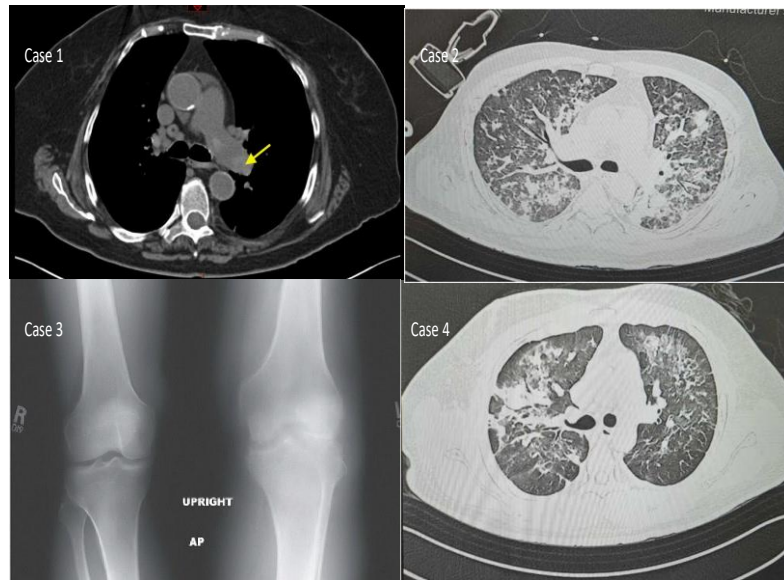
Radiological findings of patients: Case1; Computed Tomography of pulmonary angiography shows pulmonary embolism. Case2; HRCT shows features of consolidation. Case 3; X-ray right knee shows soft tissue swelling, edema, and capsular distension Case 4; HRCT shows ground glass opacity, consolidation, and interlobar septal thickening.
